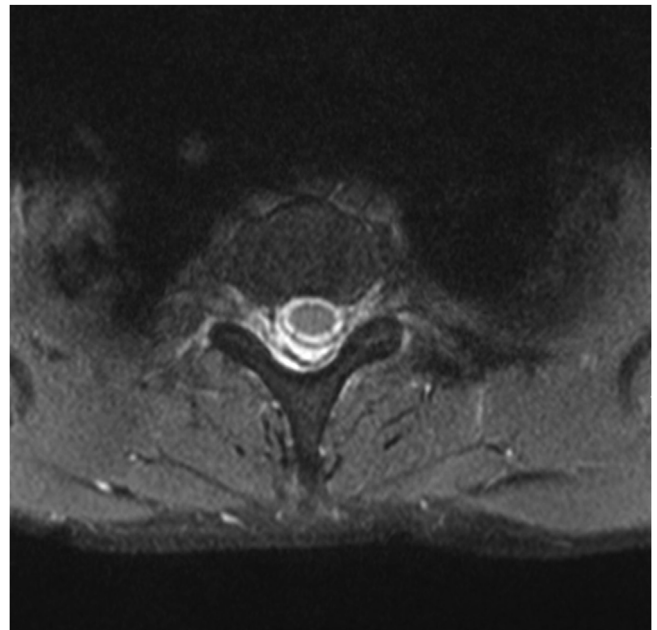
Magnetic resonance imaging of cervical spinal column.
